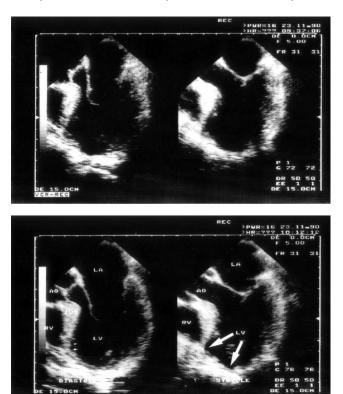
Case study: echocardiography imaging of the left ventricle of a patient with severe CHF who suffered from anterior apical MI. The top of the picture shows diastolic and systolic left ventricular measurements obtained from a patient standing out of water; the lower part was measured during immersion up to the neck. The left part indicates end-diastolic and the right part end-systolic phase of contraction.
